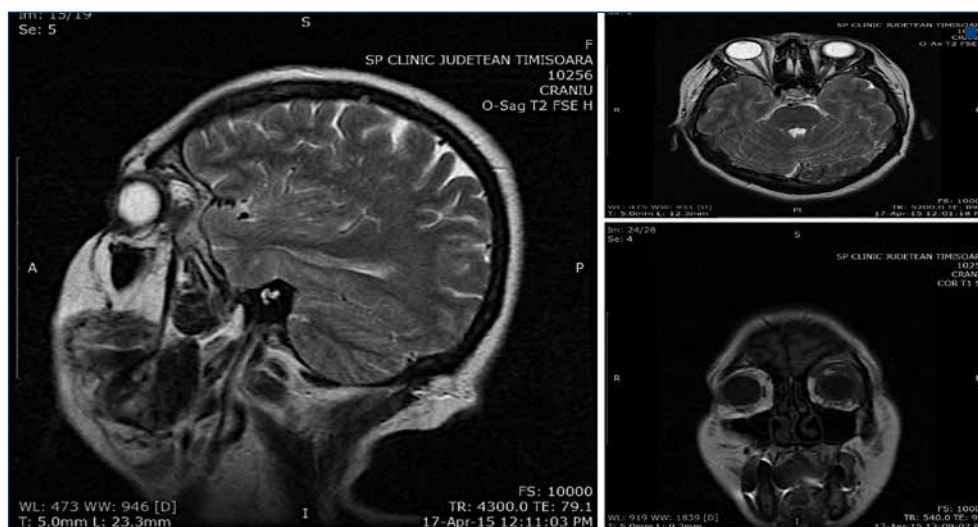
T2-MRI: Sagittal Left: intraorbital retroocular mass invading the eye muscles in ¾ quadrants, no infiltration of the optic nerve, no ischemic or other associated lesions
